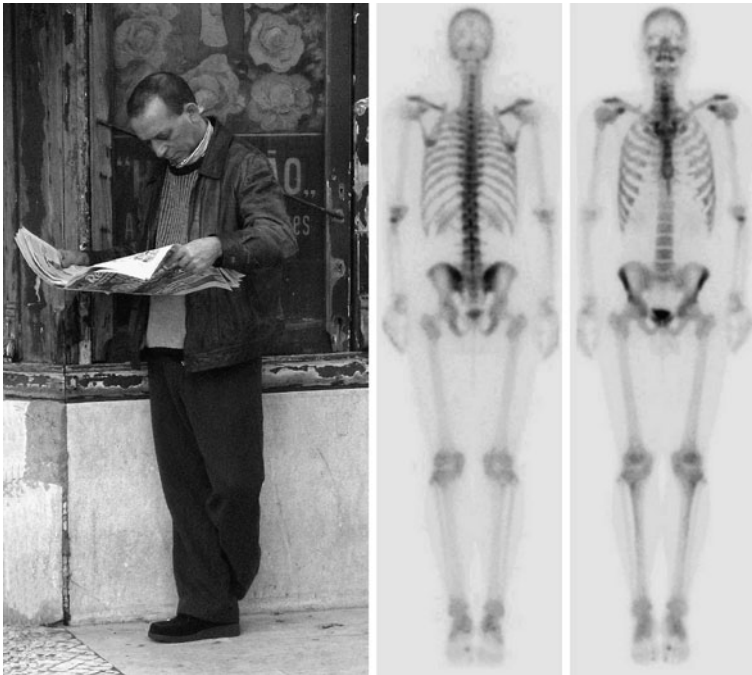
Information from a photography is quite different from that of a medical image (in this case a bone scintigraphy, published under Creative Commons license). While the human depicted in the photo looks familiar, interpretation of the *image on the right* requires expertise with respect to the meaning of the intensities. On the other hand, specific domain knowledge exists as to how to interpret image intensity in the scintigraphy and the image is acquired in a way that makes analysis as easy as possible, all of which cannot be said about the *picture on the left*. Obviously, the kind of task for computer-based image analysis is different for these two pictures
